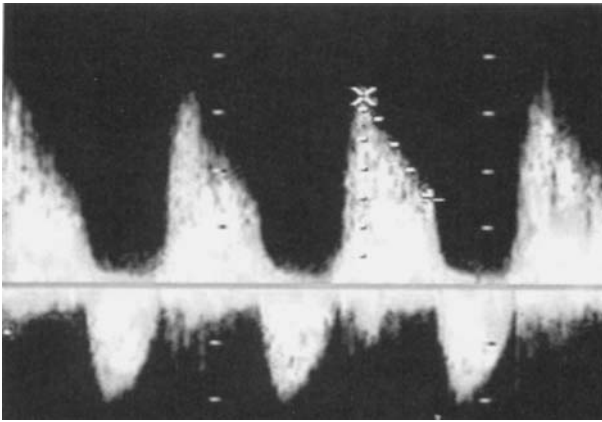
Spectral display of continuous wave Doppler made through a regurgitant aortic valve from the deep transgastric long-axis view. Aortic regurgitation (AR) flow is toward the transducer and above the baseline, and systolic outflow through the aortic valve is away from the transducer and below the baseline. Scale is 100 cm/s between each mark. The steep slope of the AR profile suggests severe AR.
